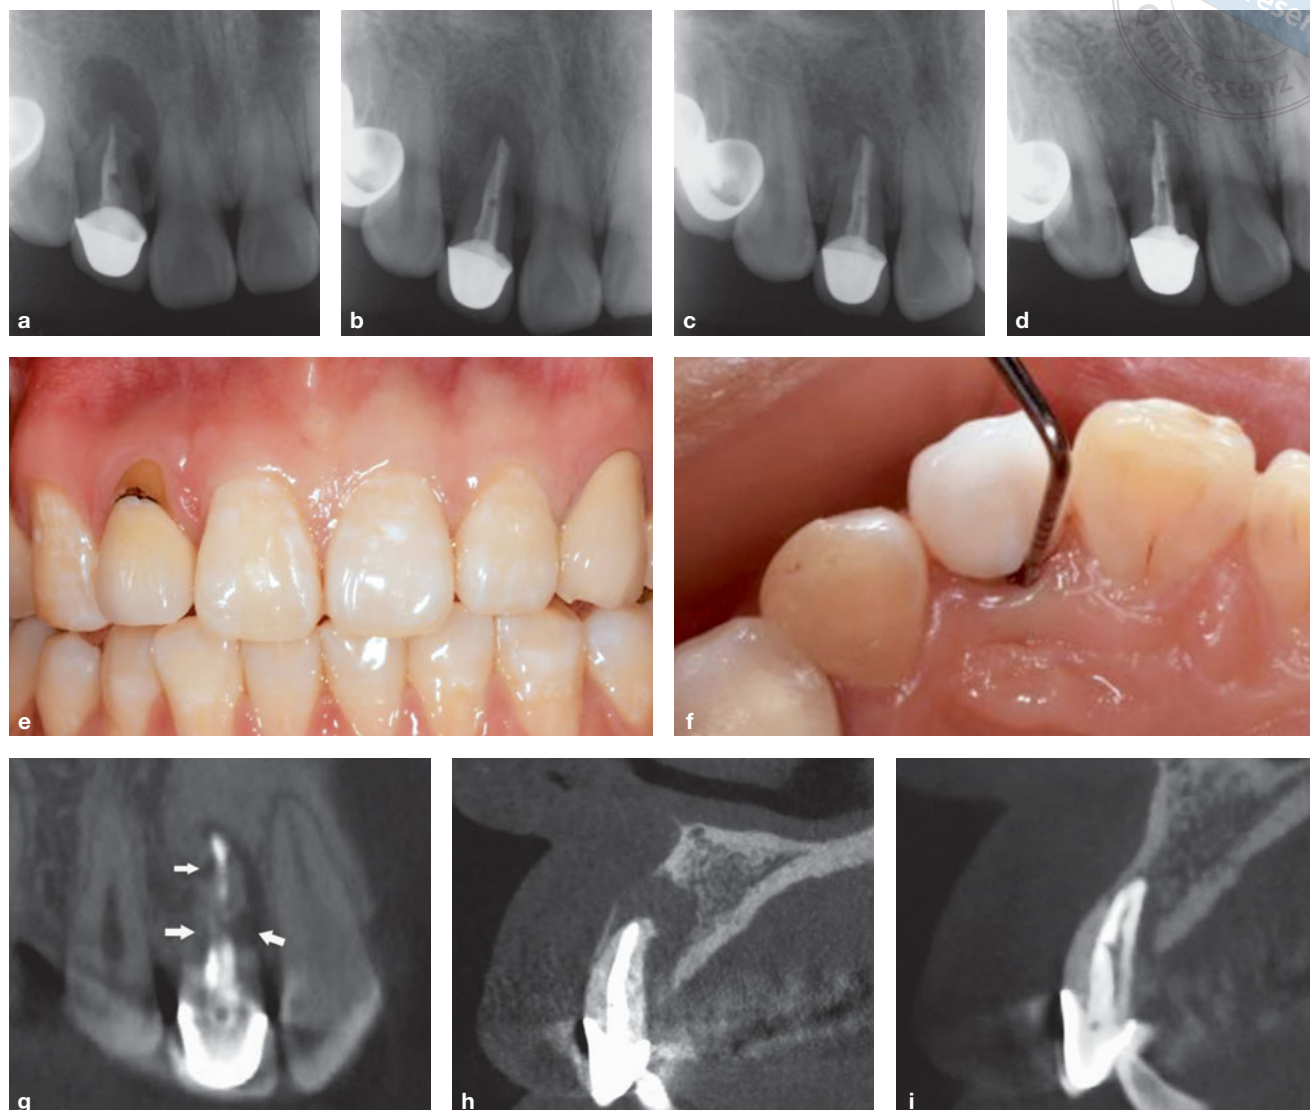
(a) Preoperative radiograph. (b) Radiograph taken at 3-month follow-up. (c) Radiograph taken at 6-month follow-up. (d) Radiograph taken at 36-month follow-up. Periapical healing was observed as time progressed compared with the preoperative situation. (e) and (f) At 36-month follow-up, the gingival papilla was well preserved, which is crucial for aesthetic restoration of anterior teeth. The mid-palatal probing depth was 3 mm. (g) External root resorption of the root was detected at 36 months (white arrow). (h) Preoperative CBCT image (sagittal view) and (i) CBCT image taken at 36-month follow-up (sagittal view). The extensive bone defect was almost repaired.
